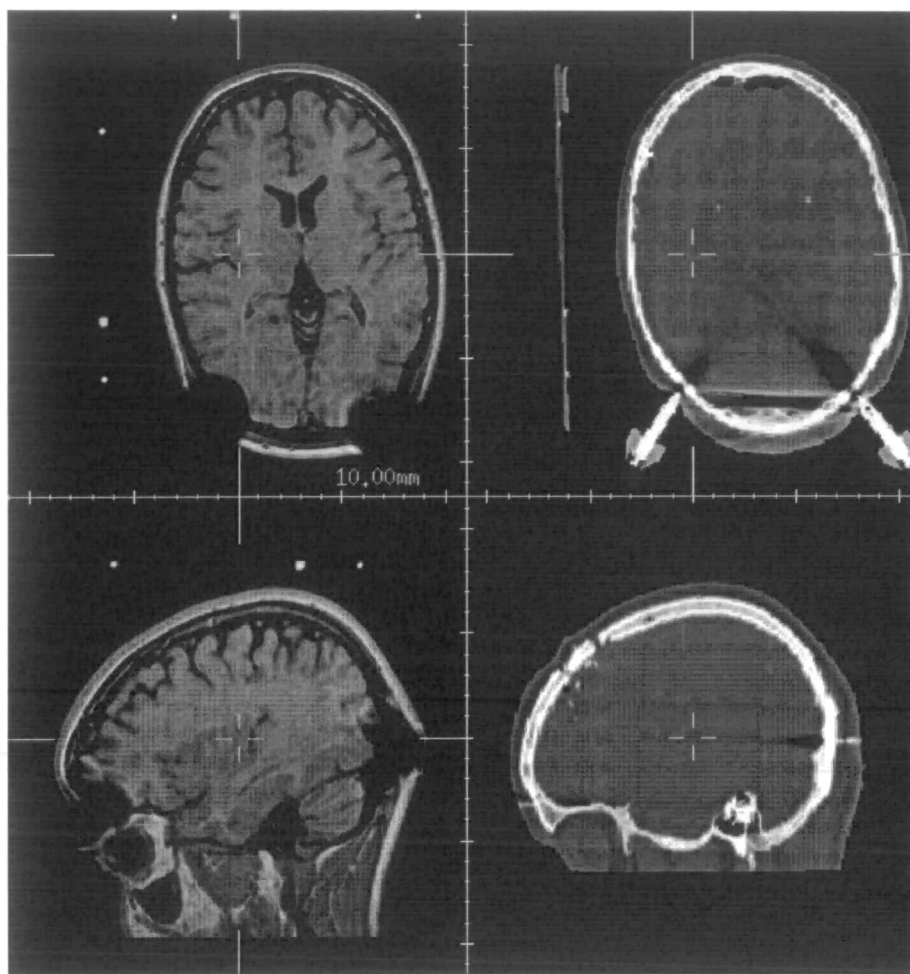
Example orthogonal slices through MR (left) and CT (right) images containing artefacts due to the presence of metal components in the stereotactic frame.
